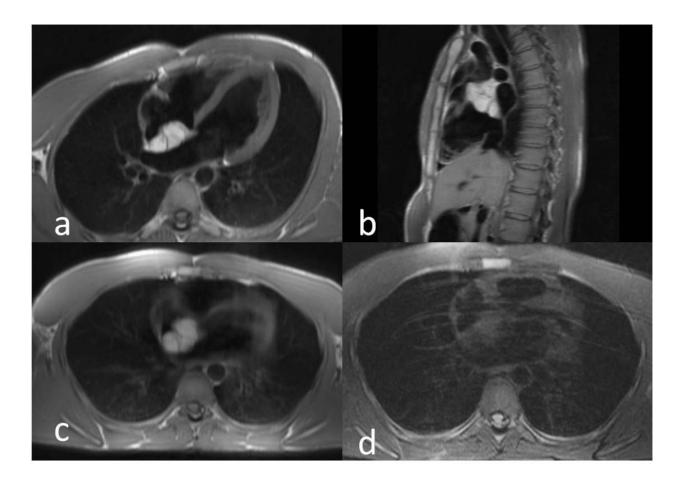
Cardiac lipoma. MRI shows a well defined focal mass with a signal intensity characteristic of fat along the interatrial septum. Note the presence of internal septa. Septa not only occur in benign lipomas but also are common in atypical lipomatous tumors and liposarcomas.
